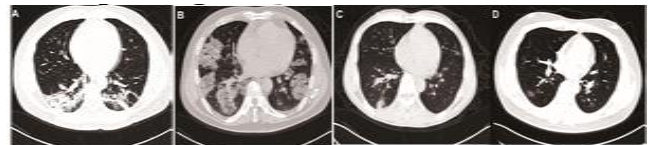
CT images on admission to hospital of patients infected with SARS-COV-2. A) Chest CT scan from a 39-year-old man with bilateral ground-glass opacities; B) Chest scan from a 45-year-old man with bilateral ground-glass opacities; C) Chest CT scan from a 48-year-old man who was discharged after nine days shows patchy shadows, and D) Chest CT scan from a 34-year-old man who was discharged after 11 days shows patchy shadows
